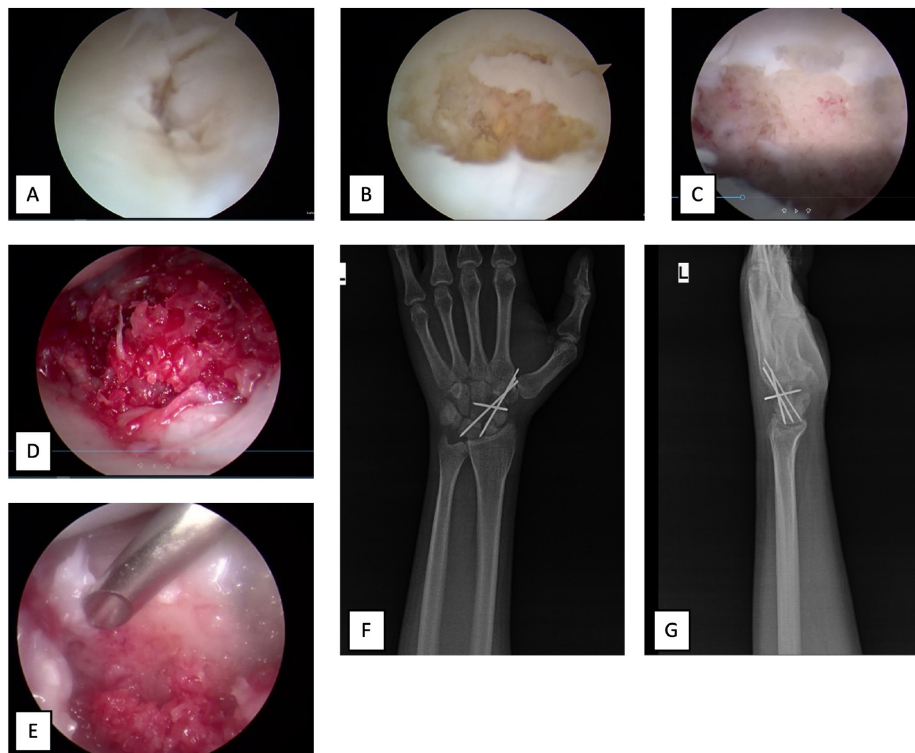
A) Arthroscopic image of scaphoid non-union, B) Debridement of fibrous tissue at the non-union line, C) Spot hemorrhages showing that we have reached the living bone tissue in the debridement procedure, D) Placing the cancellous graft taken from the iliac crest into the cavity, E) Tisseel [(Greenplast Kit, Green Cross) on the graft, Yongin Korea] tightening procedure, F) AP direct X-ray showing the stabilization of the fracture fragments and midcarpal (scapocapitate) with 3 K-wires, G) lateral direct X-ray
